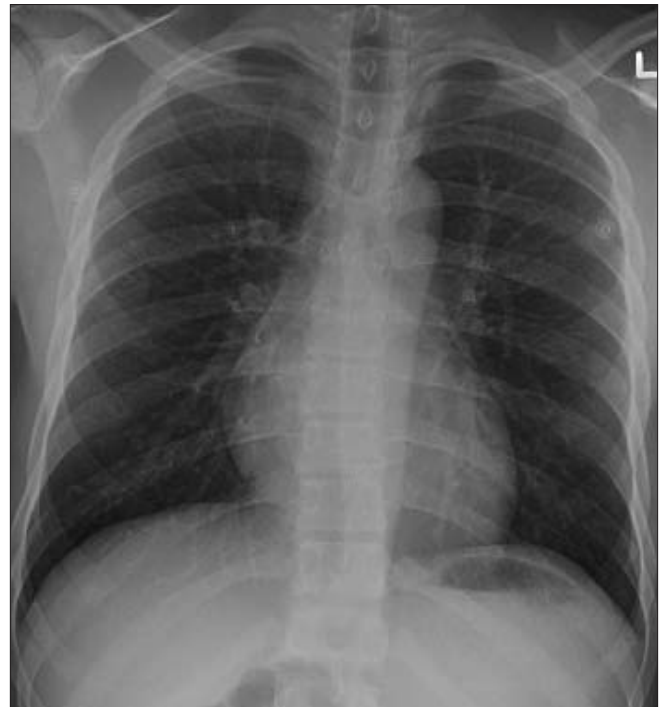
Upright chest x-ray revealing normal mediastinum and no apparent pneumothorax.
